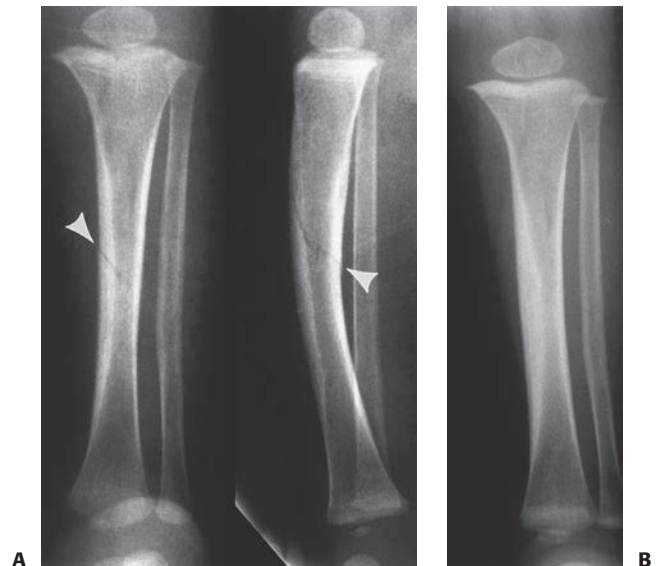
A: Anteroposterior and lateral radiographs of an 18-month-old child who presented with refusal to bear weight on her leg. Note the spiral middle one-third "toddler's" fracture (*arrow heads*). B: This fracture healed uneventfully after 4 weeks of immobilization in a cast.
